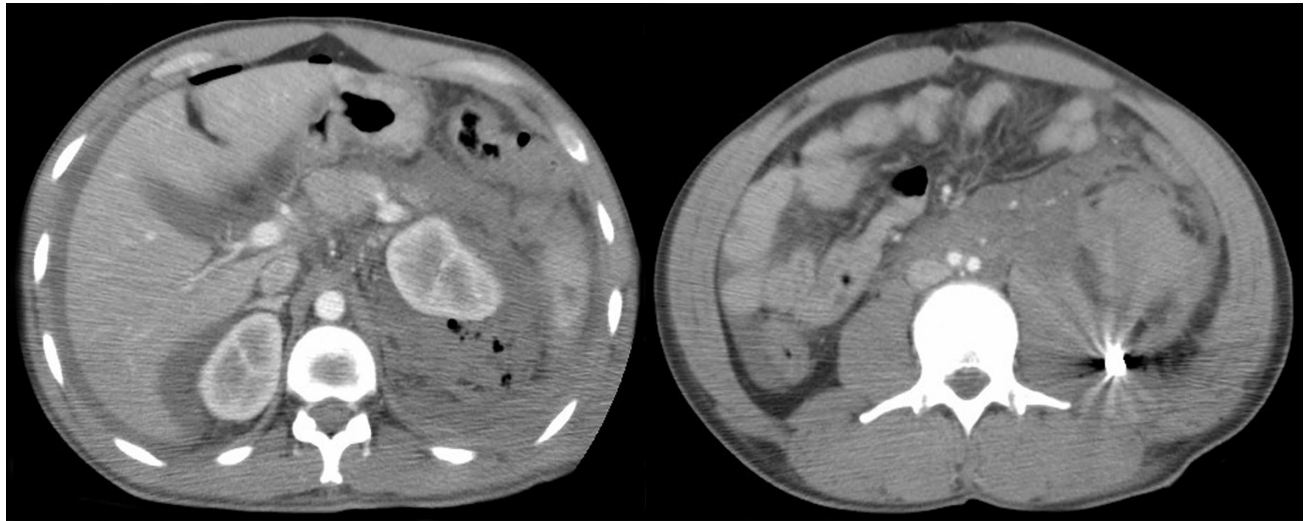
Abdominal CT images obtained postoperatively. A large perinephric fluid collection and air lucencies (Left), as well as bullet fragment (Right) are evident.
